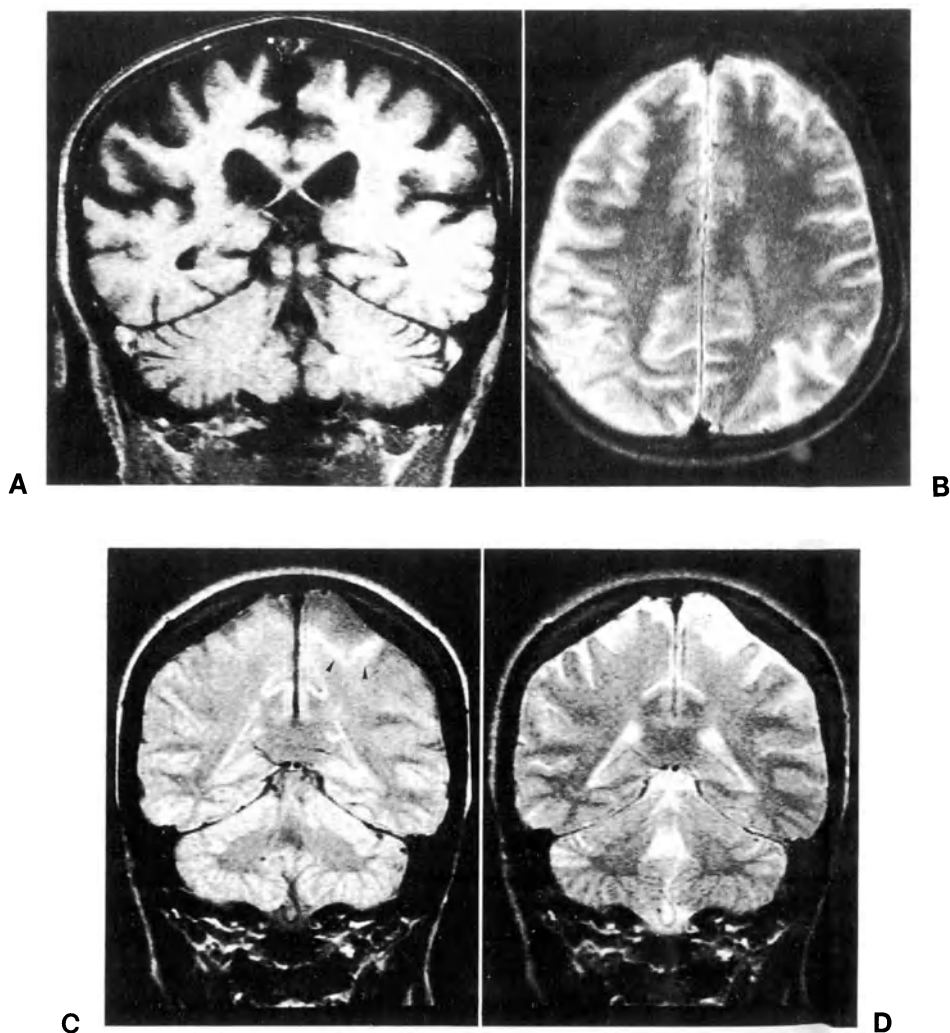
Corticobasal degeneration. Coronal T1- (A) and axial T2-weighted images (B) in the same patient demonstrate right parietal atrophy; the patient had a left alien hand. Minimal high signal intensity in the left parietal atrophic cortex was seen only in one patient in proton density images (C arrowheads); no abnormal signal intensity is recognizable in the T2-weighted image (D). This patient had a right alien hand sign
